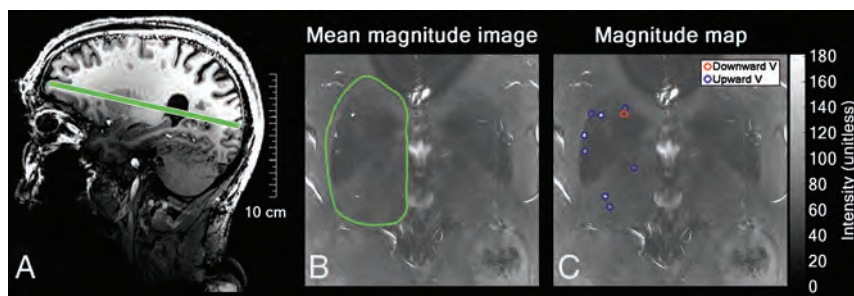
Image processing. Section position of the 2D phase-contrast acquisition through the BG was planned on the T1-weighted sequence (A). Mean magnitude image and determination of the ROI in which vessel detection was performed (B). Circles mark detected perforating vessels in the ROI, distinguishing between upward (blue) and downward (red) blood flow directions. Only vessels with an upward flow direction were considered (C), to ascertain inclusion of arteries only (no veins). *V* indicates velocity.
